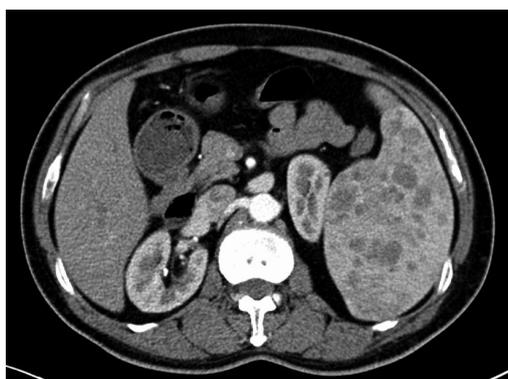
Computed tomography image of a littoral cell angioma reveals multiple splenic lesions and splenomegaly.
